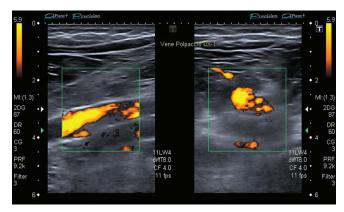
Echo color Doppler shows the thrombosis of the right popliteus veins
